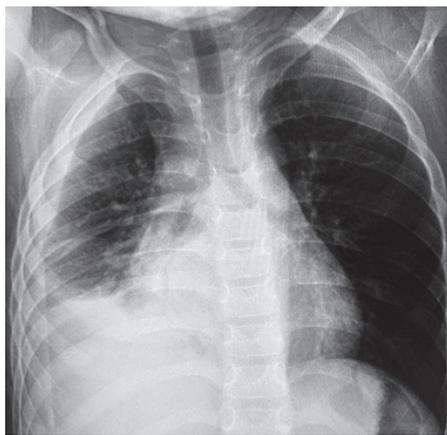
Chest radiography showing bilateral interstitial infiltration with blunt of right costophernic angle and effusion.
